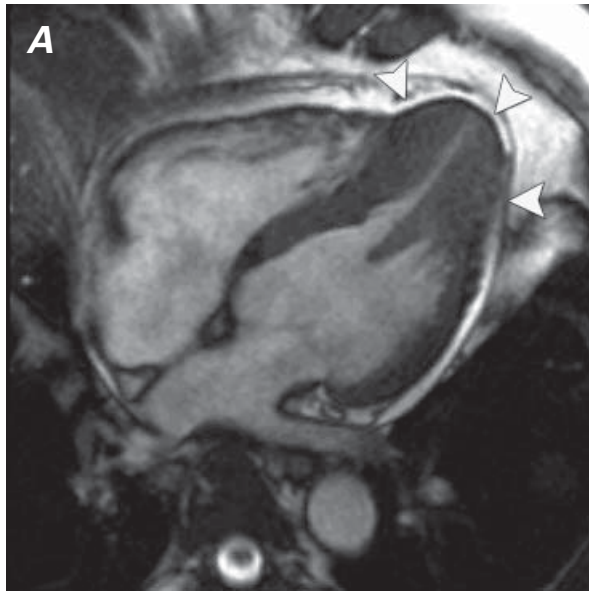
Cardiac-gated, breath-hold, gradient-echo magnetic resonance images of the heart in A) 4-chamber and B) left ventricular outflow tract views show a marked hypertrophy of the left ventricle, which is more pronounced in the apex (arrowheads).
